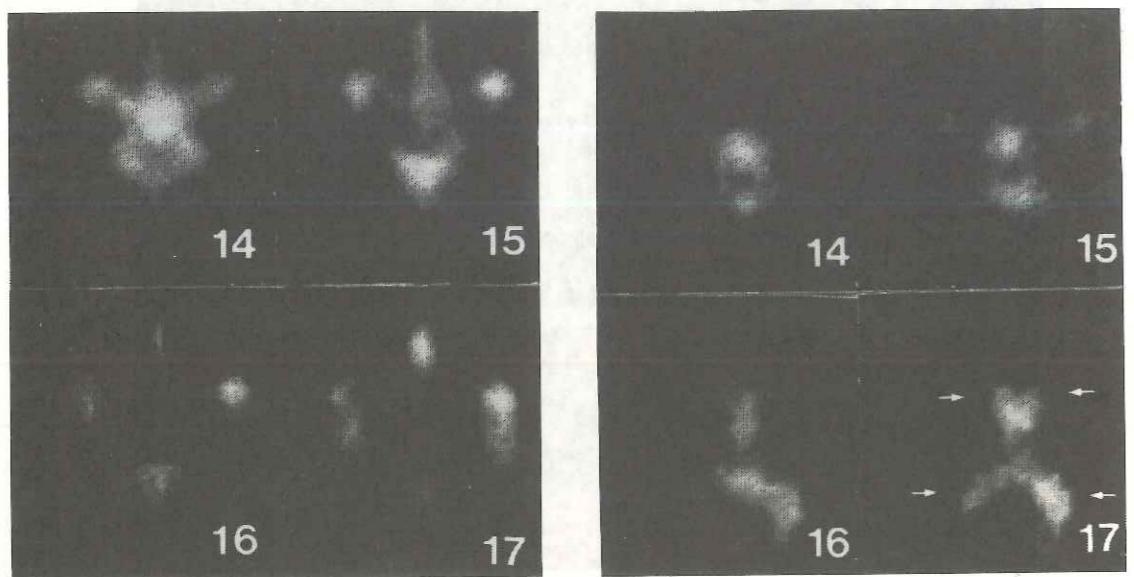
Cisternography with SPECT using 100 MBq $^{99}\text{Tc}^{\text{m}}$ -DTPA. Left: 4 consecutive sections of a normal case. Right: Pathological case with intra-ventricular distribution of the radiopharmaceutical (arrows in section 17).
